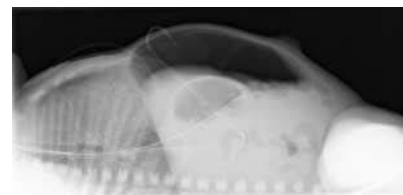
Abdominal radiograph confirming pneumoperitoneum.
